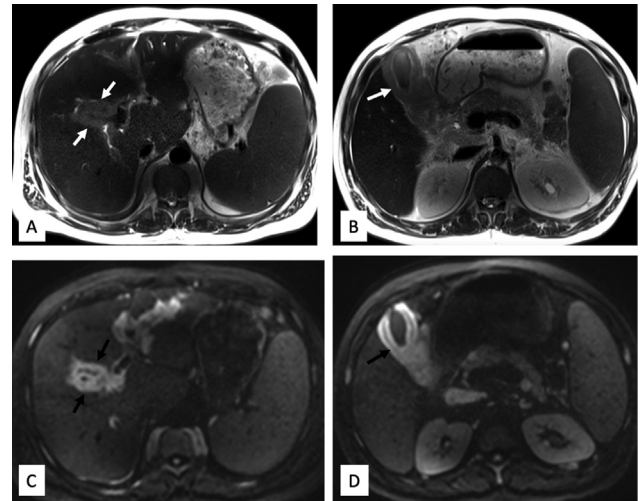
Axial T2 HASTE sequence (A) shows T2 hyperintensity in the periportal region along the left and right portal veins branches. Axial T2 HASTE sequence (B) shows homogenous hyperintense gallbladder mural thickening. Axial diffusion-weighted imaging (DWI) images (C, D) show corresponding restricted diffusion in the periportal region and gallbladder wall thickening.
